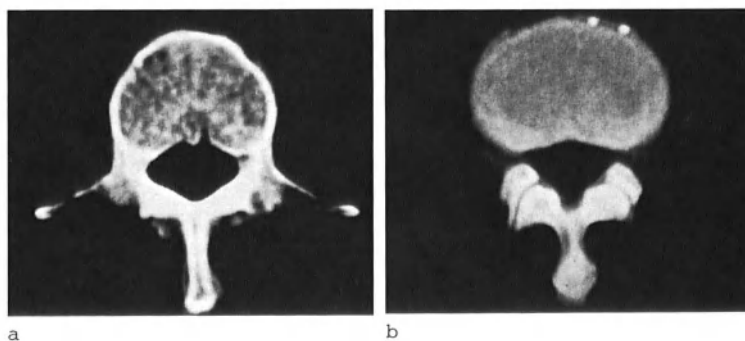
Horizontal CT sections of disarticulated spine. (a) Upper segments of vertebral body. (b) Intervertebral disc level
